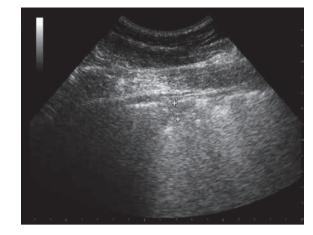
Case 1: Ultrasonographic image five weeks after starting Tulathromycin treatment. Right side of the thorax, 6th intercostal space. Small area of consolidation (1.4 cm). | *Fall 1: Ultraschallbilder fünf Wochen nach Beginn der Tulathromycin Therapie. An der rechten Seite des Thorax ist ein kleiner Bereich mit Konsolidierung sichtbar (1,4 cm).*
